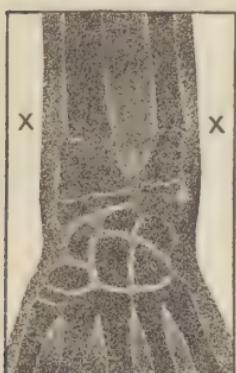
From an X-ray photograph of a broken forearm and a wrist. The crosses show where the bones are broken.
